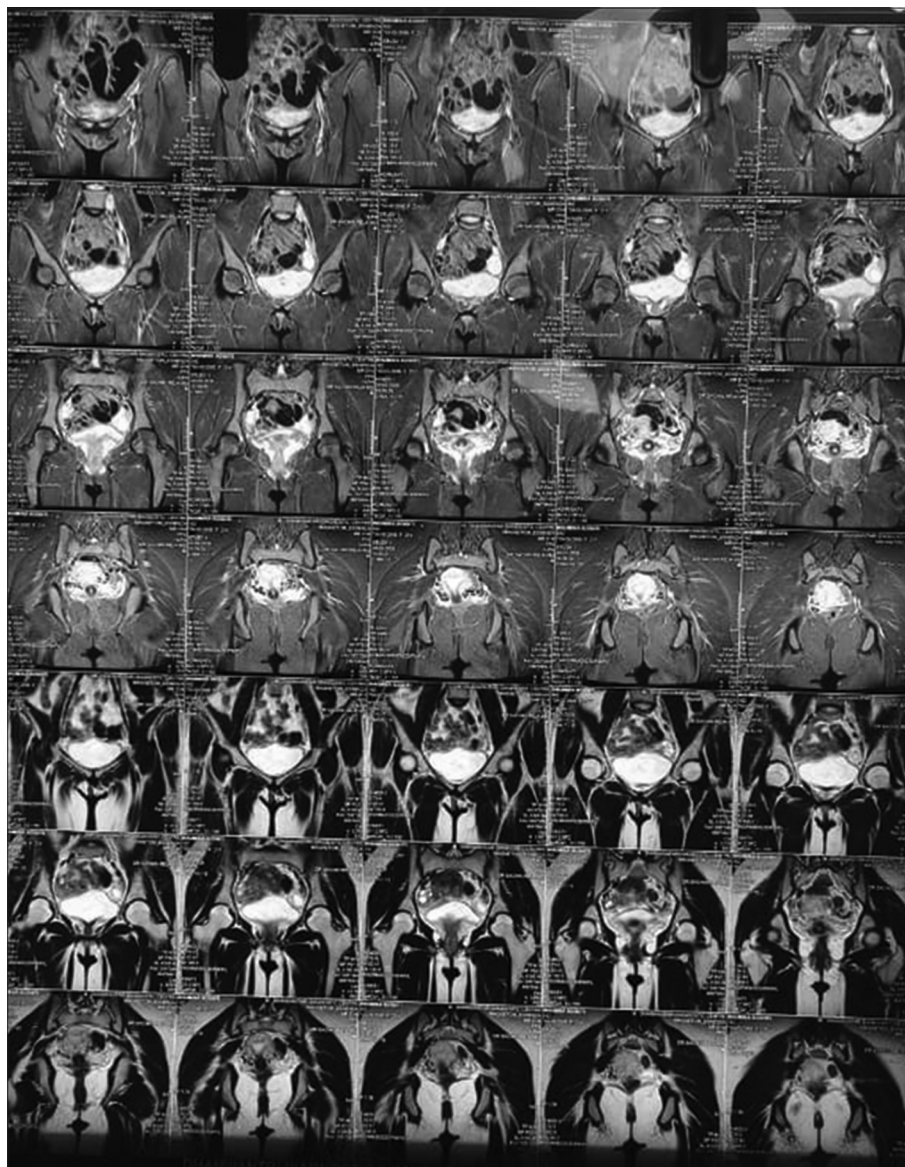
Magnetic resonance imaging-based anatomical localization of the heterotopic ossified mass in the parasymphyseal region extending into the left labia majora. The lesion is clearly separated from the pubic bone, confirming an extraskelatal origin
